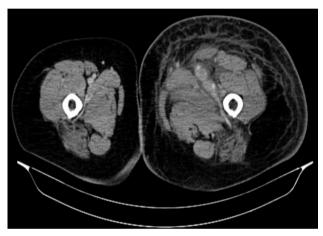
Preoperative CT scan: extended thrombosis of the left femoral vein, external iliac vein, internal iliac vein, and left common iliac vein.
